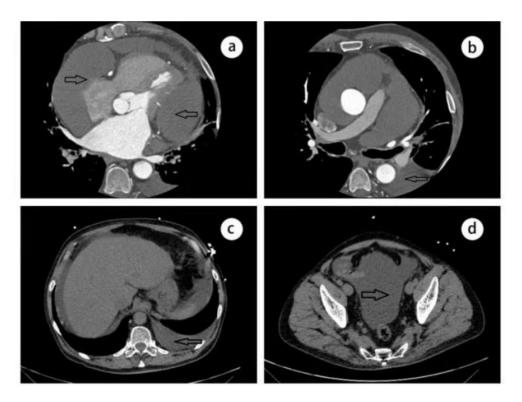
Computed tomography revealed massive pericardial effusion (A, arrows), left pleural effusion (B, arrows), seroperitoneum (C, arrows), and massive pelvic effusion (D, arrows).
